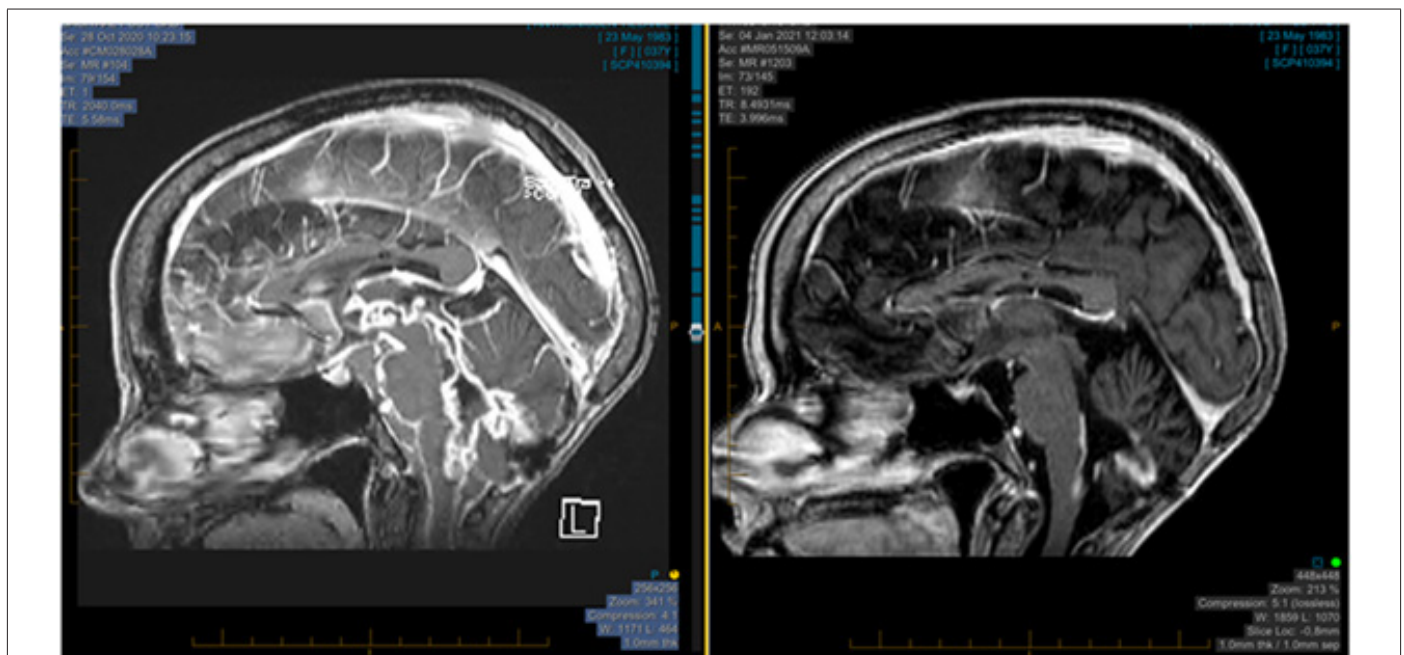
T1-contasted MRI performed prior to chemotherapy (a) and after 3 cycles (b).
